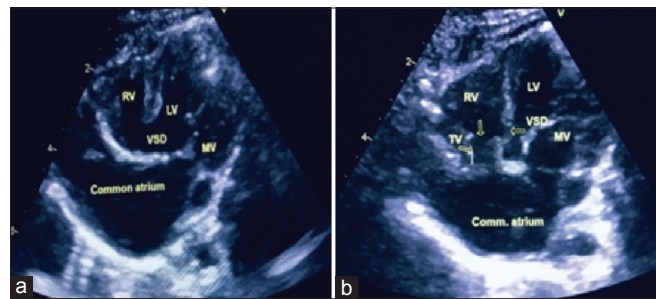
Transthoracic echocardiography in systole (a) and in diastole (b)
